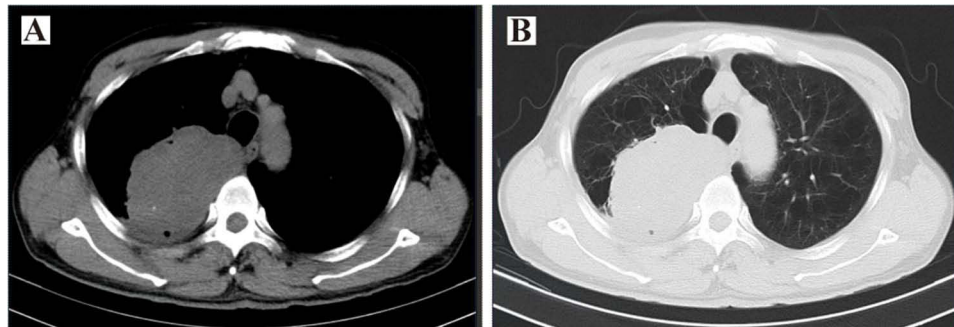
Representative chest CT images of *SMARCA4*-dNSCLC. (A) Axial chest CT (lung window) showing a large soft tissue mass in the right upper lobe with speculated margins and internal calcifications. (B) Axial chest CT (mediastinal window) showing displacement of the right upper lobe bronchus and patchy ground-glass opacities in both lungs.
